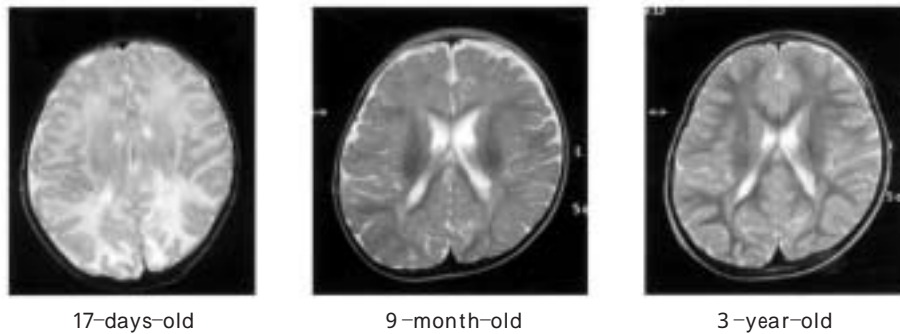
Brain MRI. At the age of 17 days, the patient's white matter and a part of cortex showed T2 prolongation in bilateral parieto-occipital lobes. At the age of 9 months, white matter and a part of the cortex T2 prolongation was localized and scarred. Trigone was dilatated, and the peripheral lesion T2 was prolonged. At the age of 3 years, white matter and a part of the cortex T2 prolongation was more localized than before, and the terminal zone T2 was prolongation. The ventricles were dilatated.
